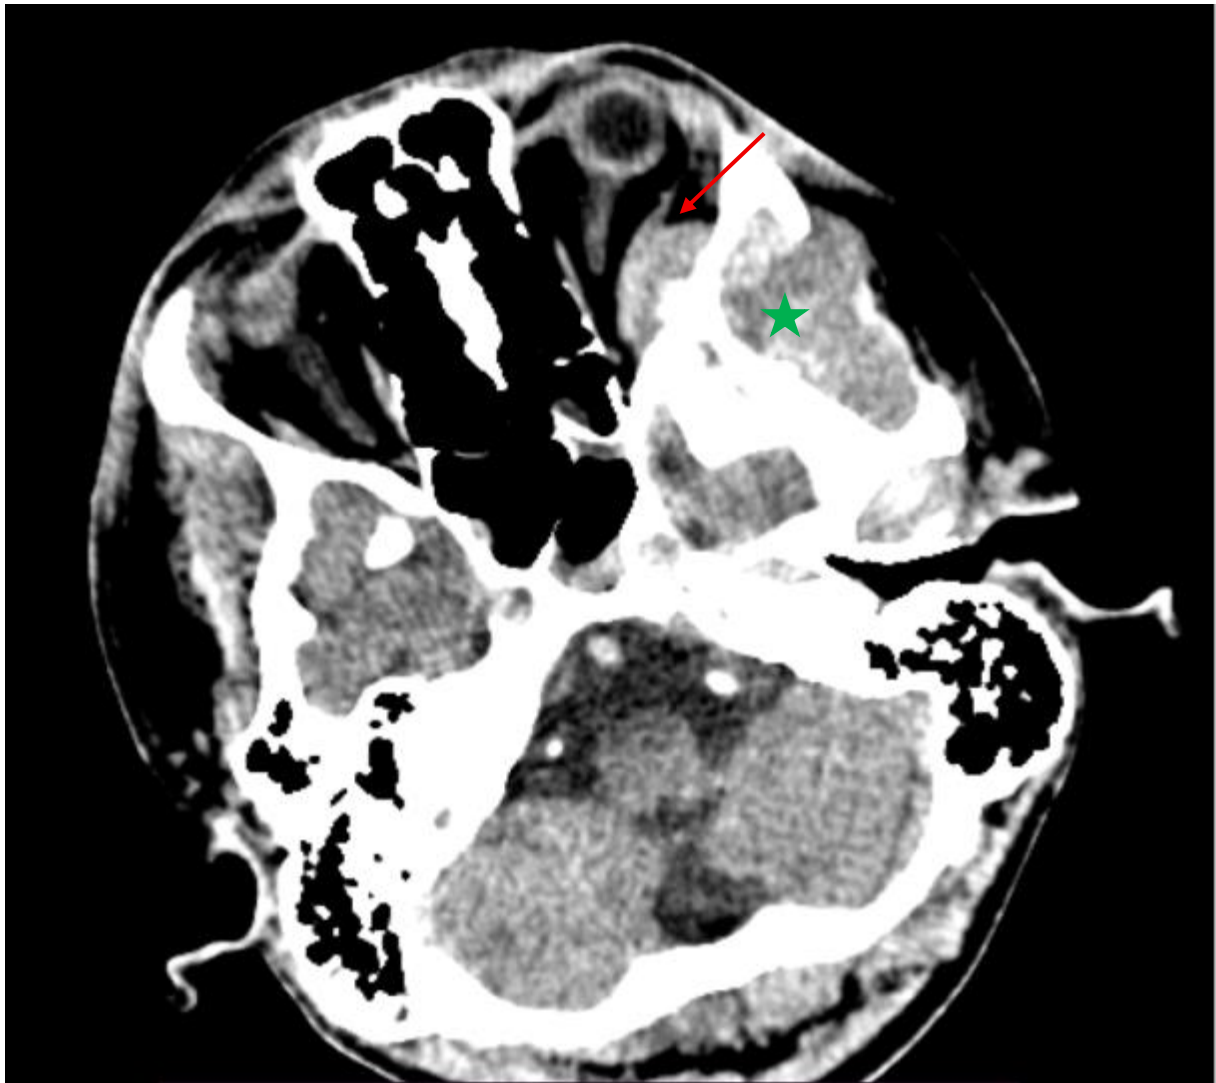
Axial CT scan (soft tissue window) showing the lesion (green star) causing mass effect on the lateral rectus muscle (red arrow), displacing the globe anteriorly.
